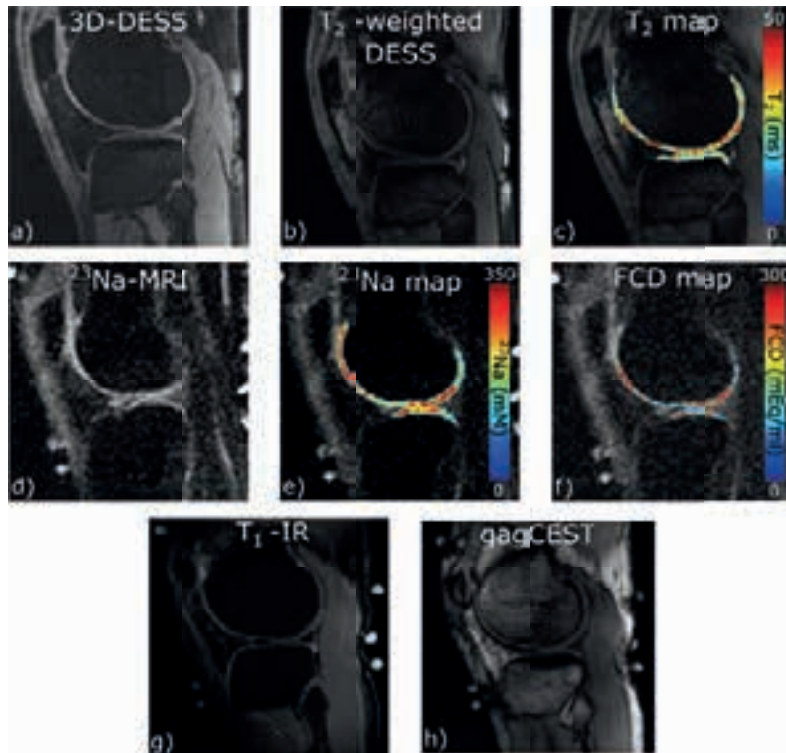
A sagittal slice from the lateral tibiofemoral compartment of a knee joint of an asymptomatic male subject imaged at 7.0T with a) a proton density 3-D Dual-Echo Steady State sequence, b)  $T_2$  weighted Dual-Echo Steady State sequence and c) calculated  $T_2$  relaxation time map (from b)), d) Sodium ( $^{23}\text{Na}$ ) MRI with Spoiled gradient recalled echo (SPGR) sequence and the calculated e) sodium and f) fixed charge density maps (from d)), g) an  $T_1$  weighted Inversion Recovery sequence and h) GAG-specific Chemical Exchange Saturation Transfer image.
